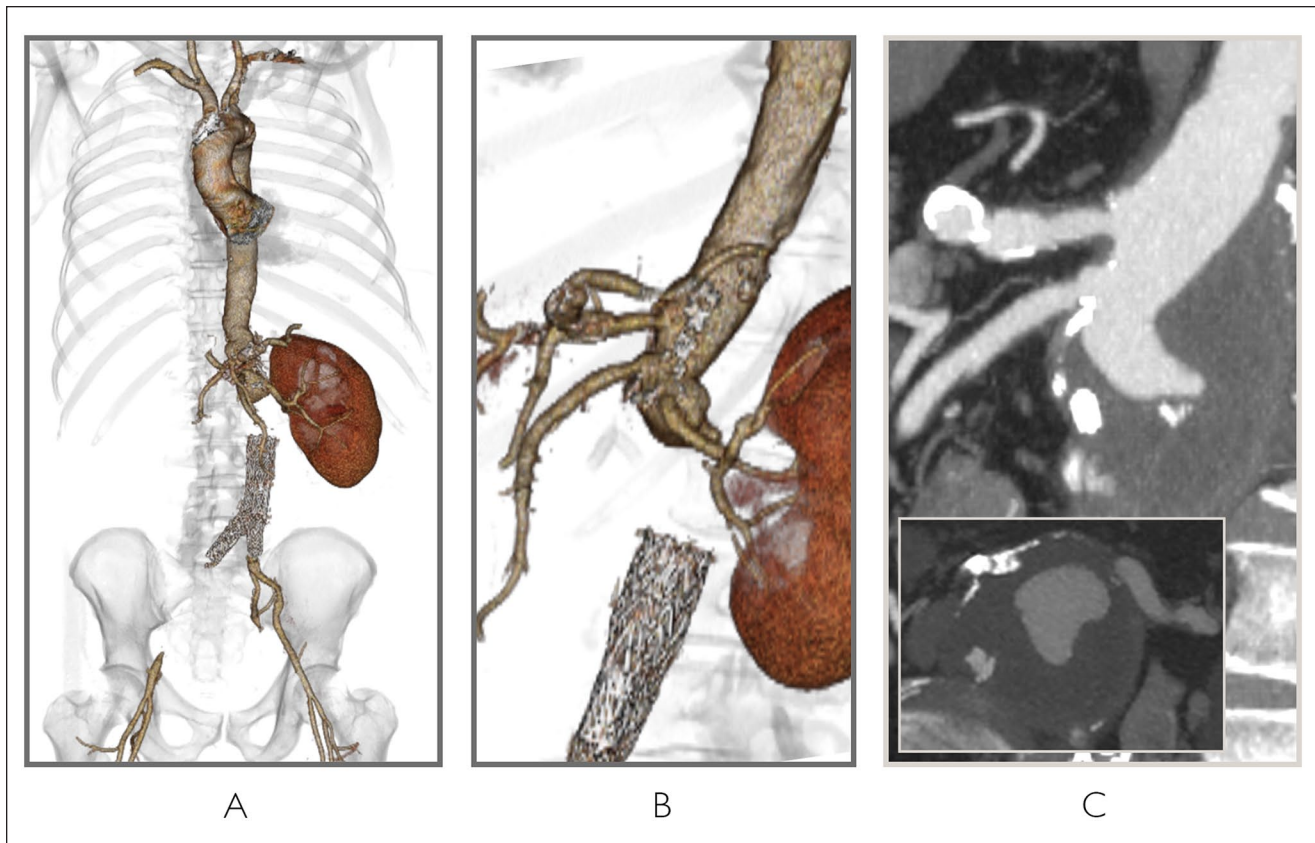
Preoperative computed tomography angiography (A, B: 3D volume rendering; C: multiplanar reconstruction and axial scan). The patient was previously treated with thoracoabdominal aortic aneurysm open repair with inclusion technique, infrarenal abdominal endovascular repair, and right renal stenting. The images show a recurrent visceral aortic patch aneurysm associated with occlusion of the pararenal aorta, the right iliac axis, and the right renal artery.
